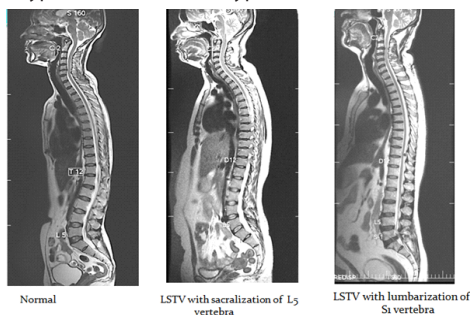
MRI T2 spin-echo weighted images of the whole spine showing
